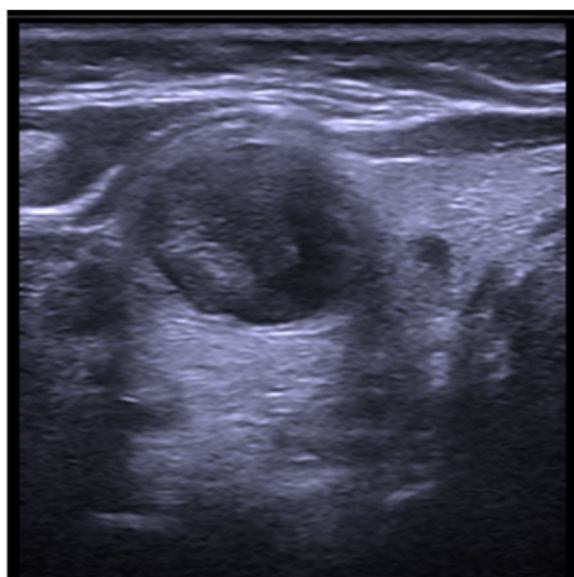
Different sonographic patterns of thyroid nodules. TR4: Solid hypoechoic nodule
